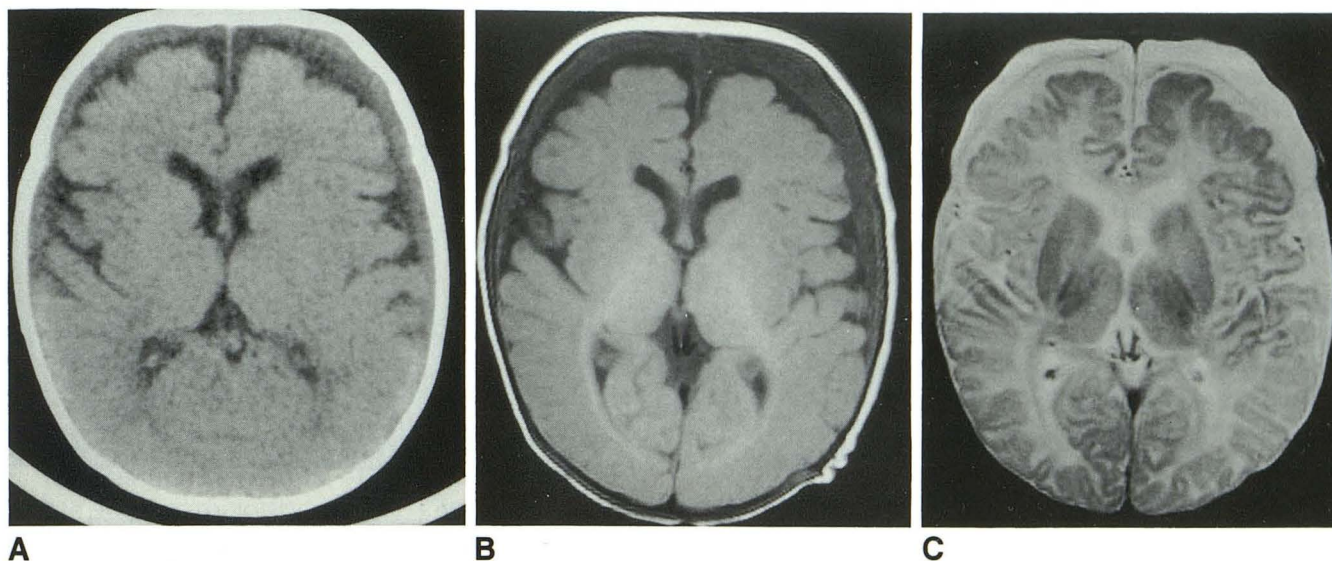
Subdural collection: positive CT scan.
